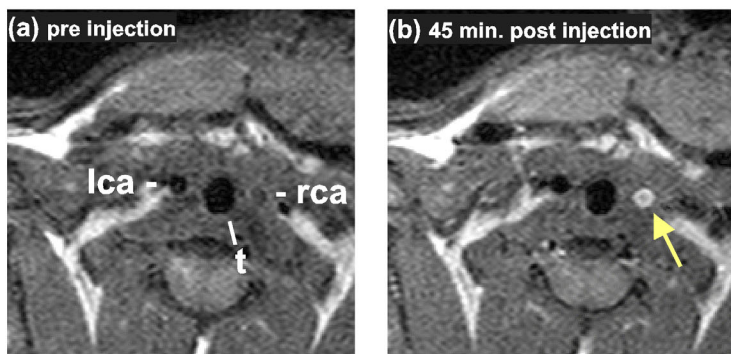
Transversal MR images through neck area, as measured (a) pre and (b) 45 min. post injection with Gd-liposomes. (lca=left carotid artery, rca=right carotid artery, t= trachea).
